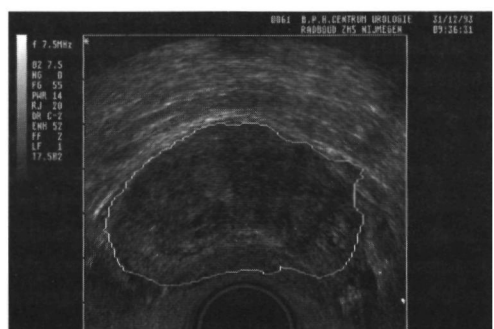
the ultrasound image with the projected contour.*
